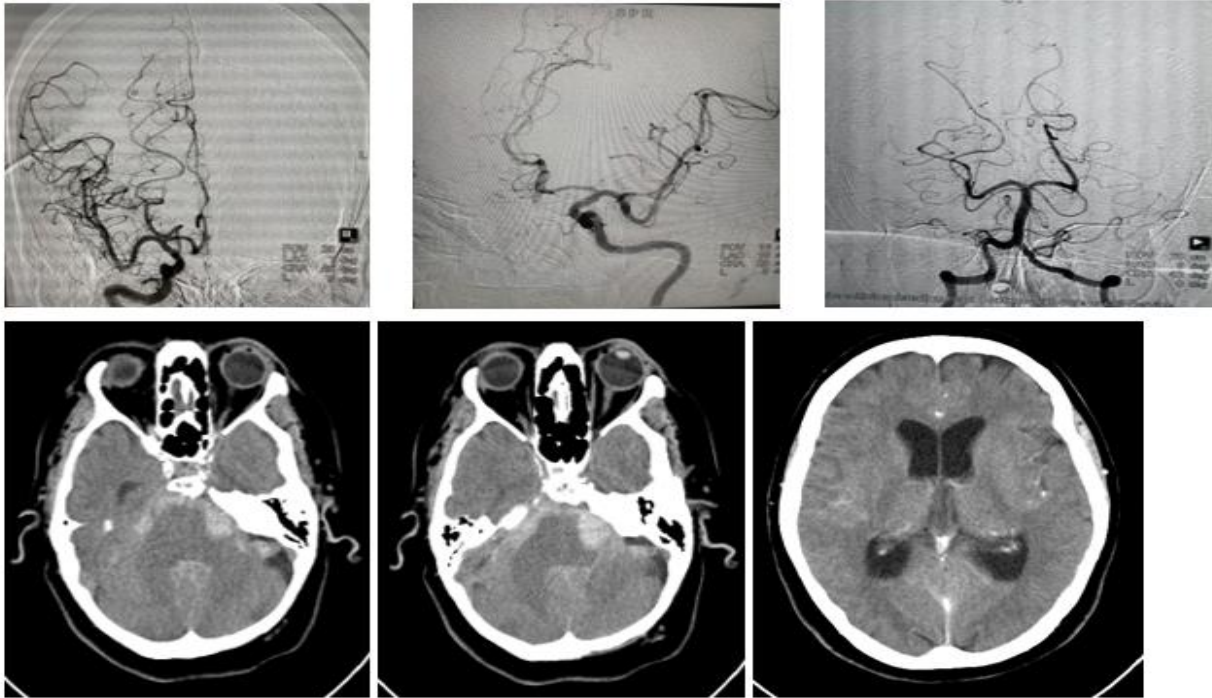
Angiography (a), plain CT brain (b, c, d) of the case No (1).
